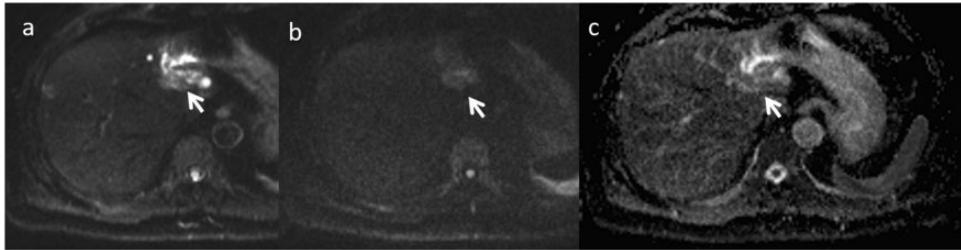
Same patient as in Figures 2–4. DWI sequences: (a) b value = 50 s/mm², (b) b value = 800 s/mm², and (c) ADC map. The lesion showed a restricted signal (arrow) with hypointense signal on ADC map (arrow).
